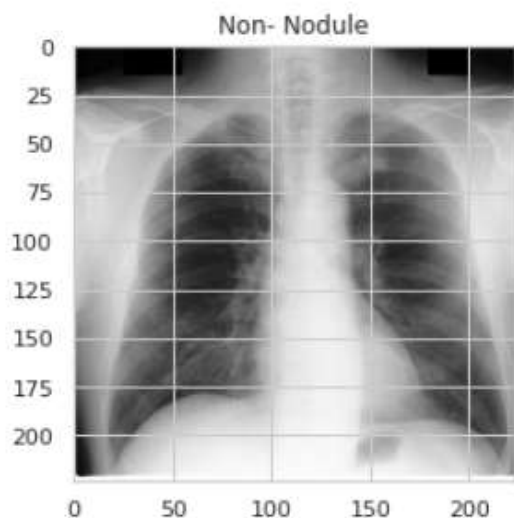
X-ray Showing Non Nodule Image with pulmonary readings
